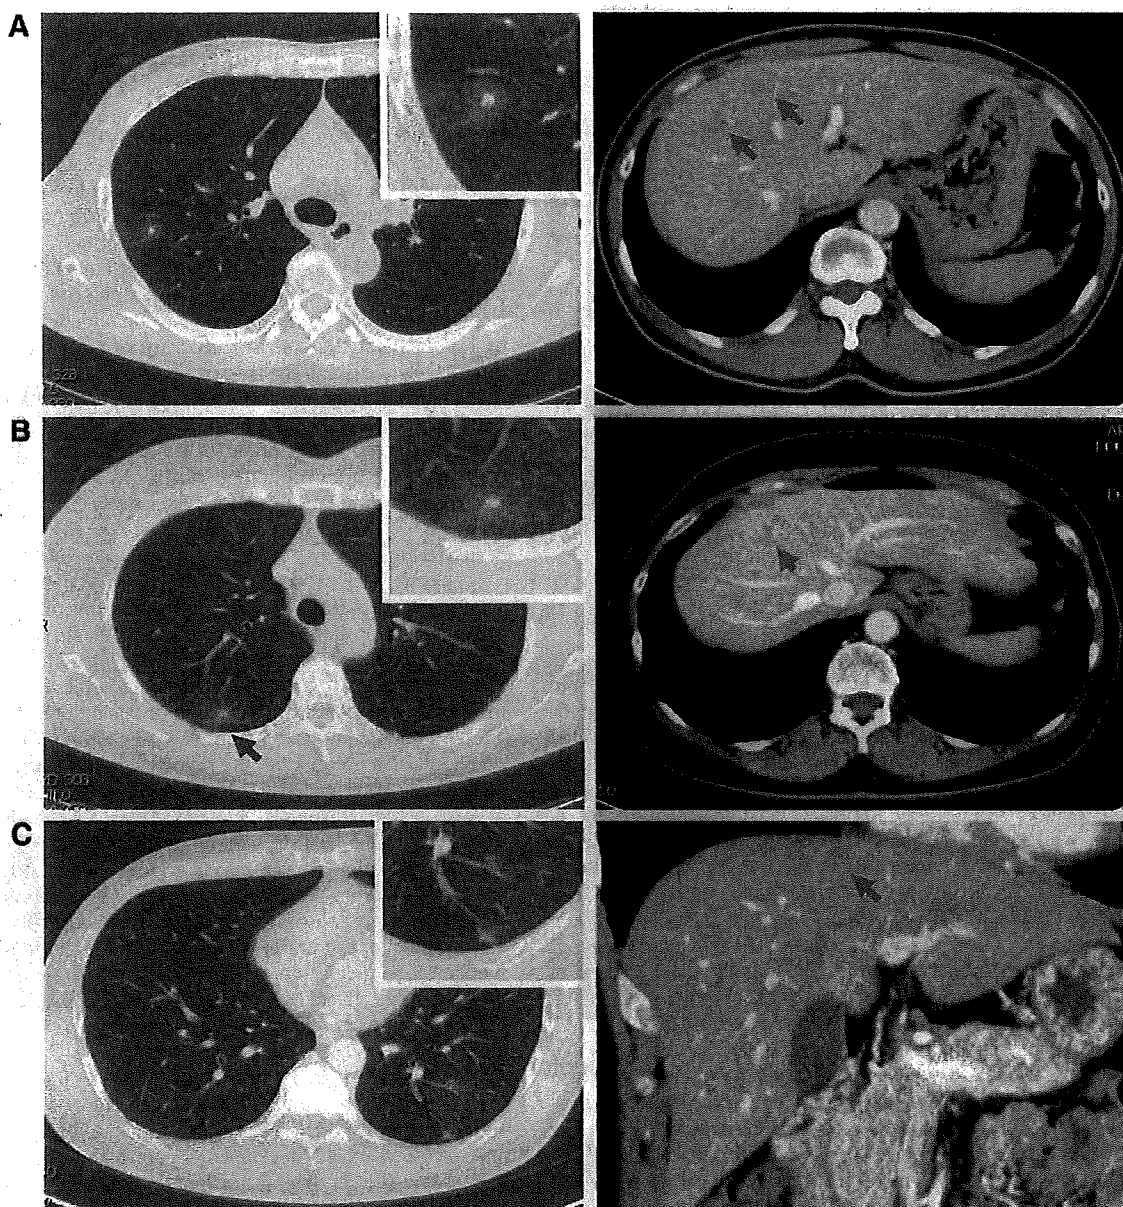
CT images of pulmonary and hepatic lesions. A, B, and C show representative CT images from Patients 1, 2, and 3, respectively. Pulmonary lesions (arrows, magnified in inset) were shown as nodules with halos and a poorly defined margin or ground-glass opacity with a poorly defined margin. Hepatic lesions (arrows) appeared as small, poorly defined areas of low-attenuation in the portal venous phase of contrast-enhanced CT scanning.
